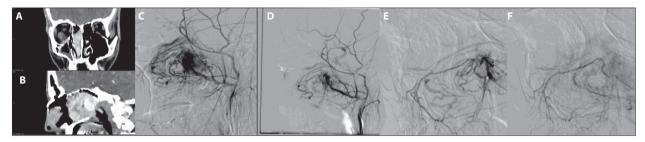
A – coronal and B – sagittal contrast-enhanced computed tomography showed tumor mass in the right nasal cavity; C – right and D – left external carotid artery digital subtraction angiography demonstrated pathological vascular network; E and F represent superselective angiograms
